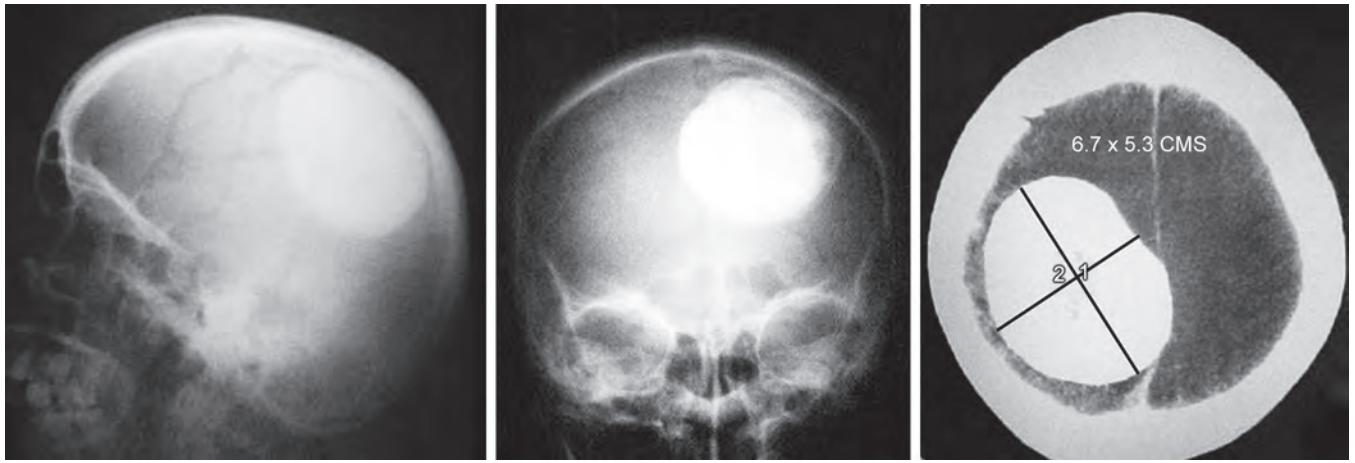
Plain radiographs and plain CT scan of a parietal convexity meningioma showing extensive calcification
